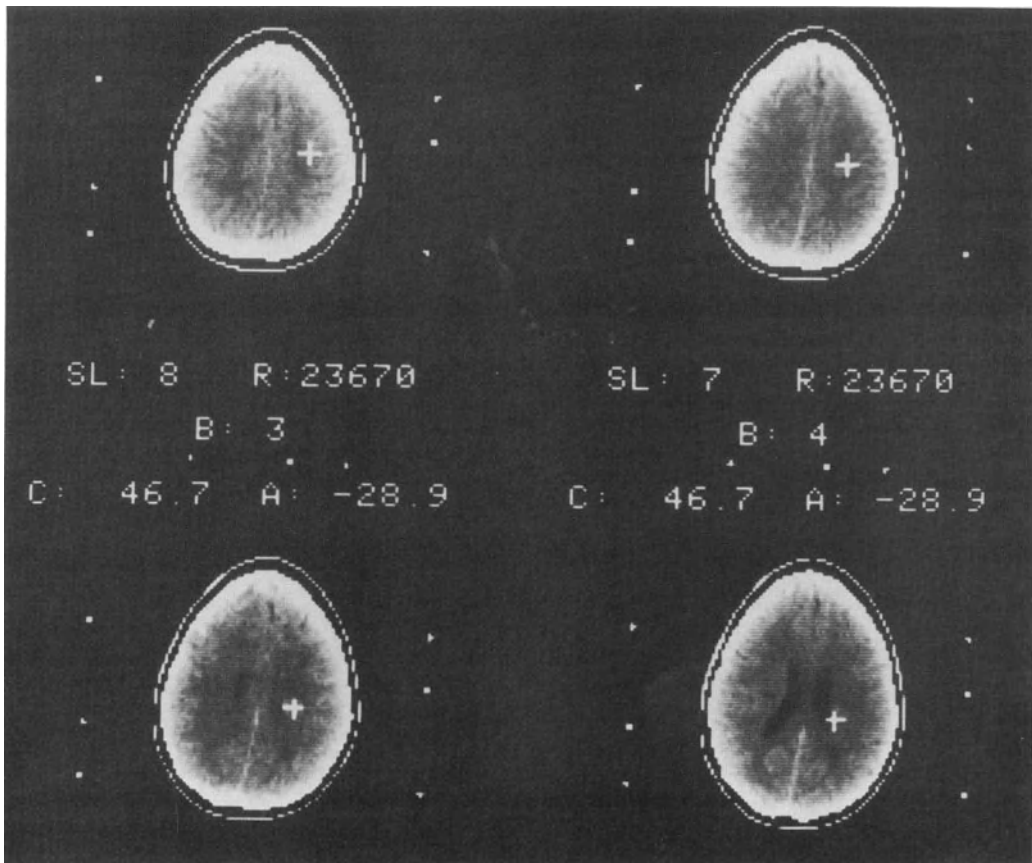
The computer demonstrates a probe tract on the contiguous CT images of a patient with a low-grade astrocytoma in the left frontoparietal region.
